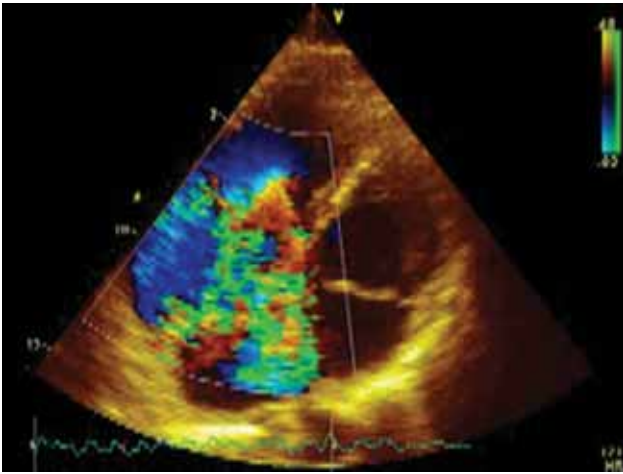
Transthoracic echocardiography (TTE) -Color Doppler study shows severe tricuspid regurgitation.
